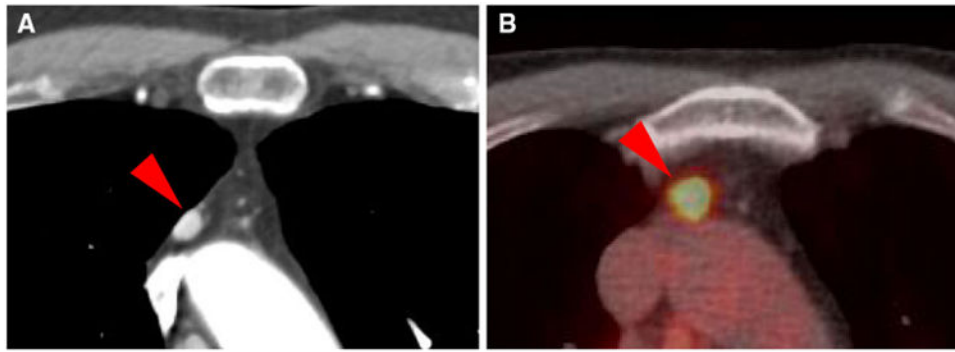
4-mm intensely radiotracer-avid anterior mediastinal lymph node (SUV_{max} 19.3) from patient #2, as demonstrated on contrast-enhanced CT (a) and ^{18}F -DCFPyL PET/CT (b) (arrowheads)
